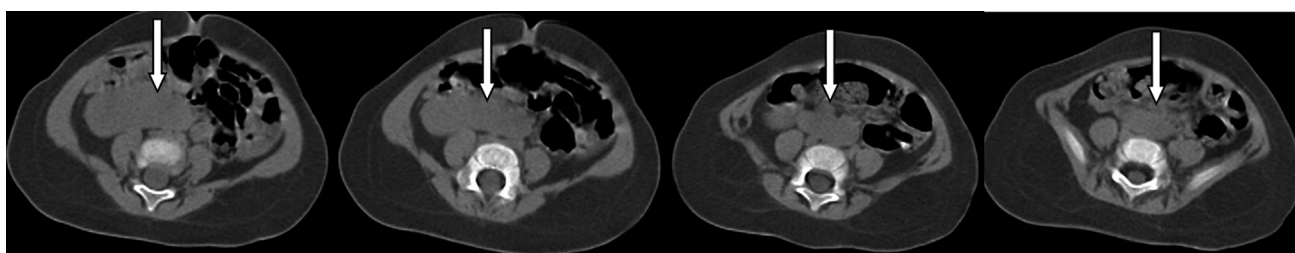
Computed tomography (CT) of the baby at around 7 months postnatal showing no corticomedullary differentiation in both kidneys.
